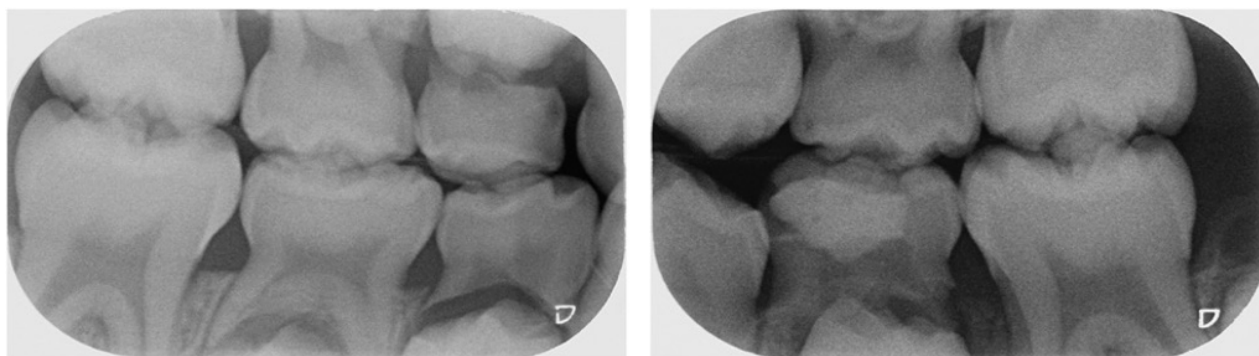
Grade 1 right and left bitewing radiographs in an 8-year-old.
